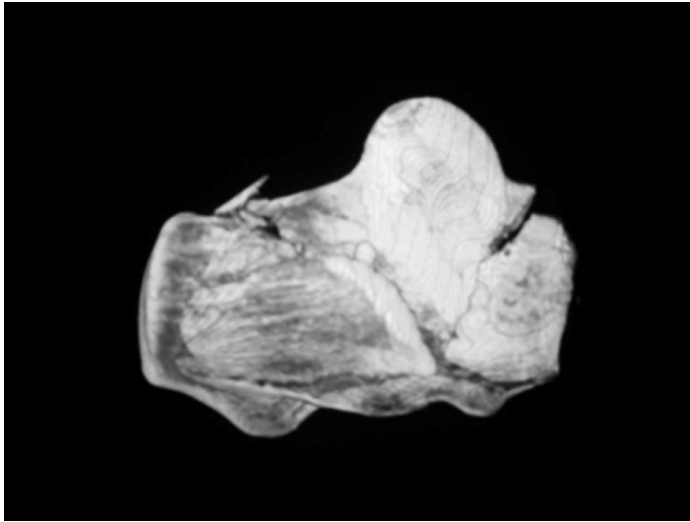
3D-CT showing horizontal depression:
